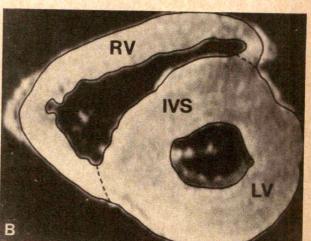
A, cross-sectional cardiac nuclear magnetic resonance image in (A) left ventricular short-axis plane. B, same image as in A with hatched borders included to define digitized right ventricular plus ventricular septal areas. IVS = interventricular septum; LV = left ventricle; RV = right ventricle.
